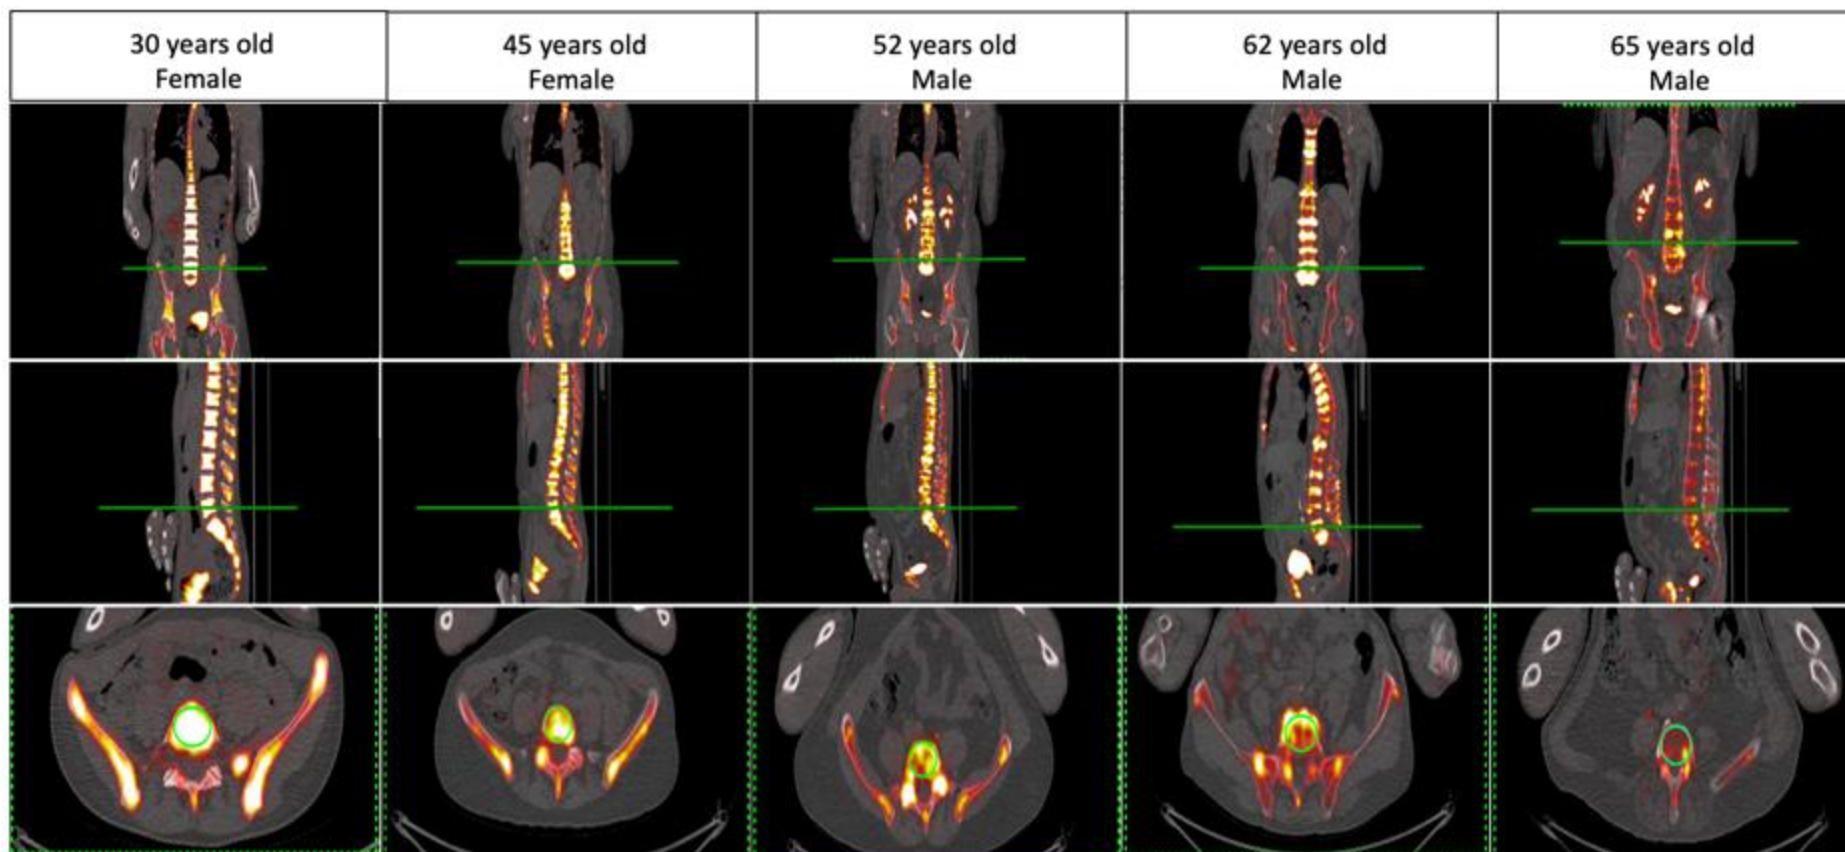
Coronal, sagittal, and axial spine fused ^{18}F -NaF PET/CT images for AKU patients.
